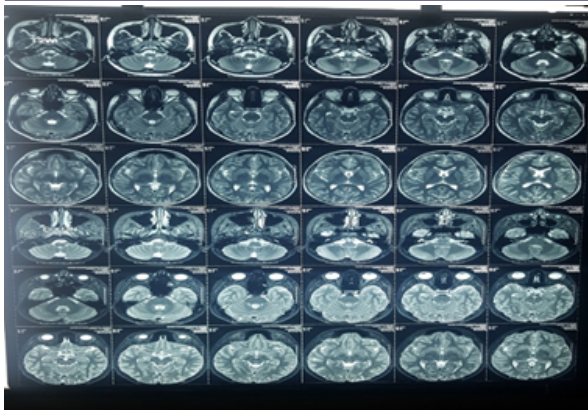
MRI BRAIN AND ORBIT
